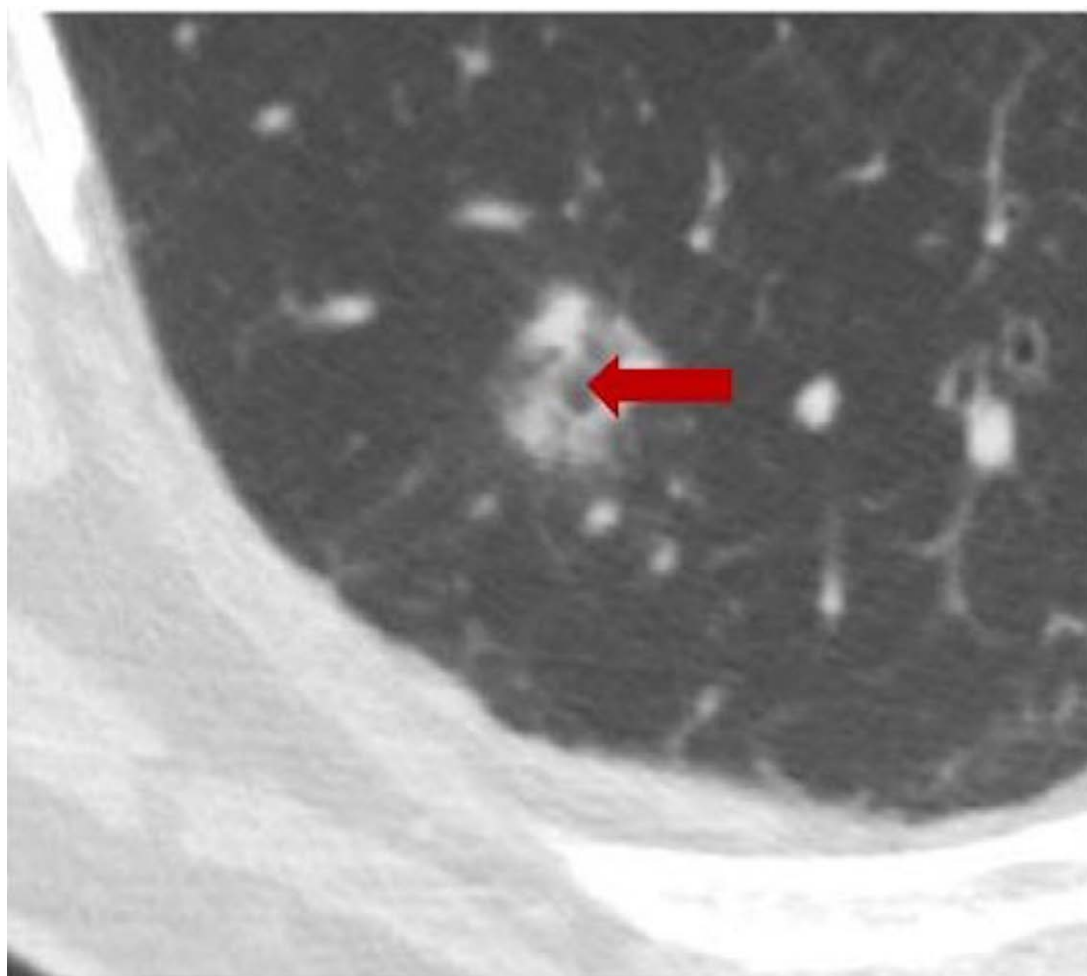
An axial CT scan with lung window settings showing a subsolid nodule containing a pseudocavity (arrow) in the right lower lobe. Pathological examination revealed it to be an adenocarcinoma.
